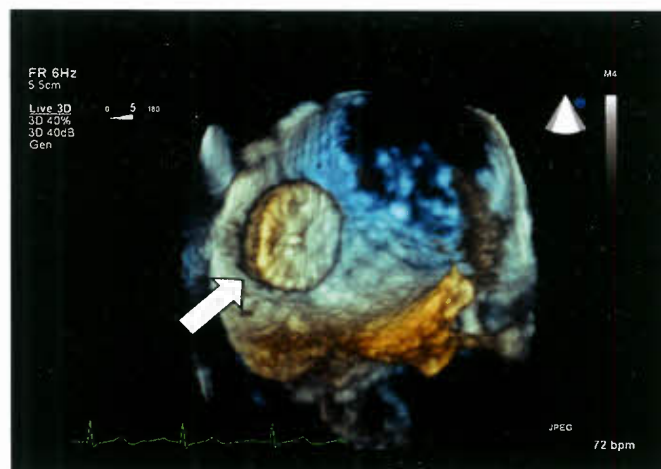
Real-time, three-dimensional transesophageal echocardiogram after deployment of an atrial septal defect occluder device. The left atrial disc of the device can be seen centrally along the left atrial aspect of the interventricular septum (arrow). (Image courtesy of Phillips Medical Co., Bothell, WA.)
